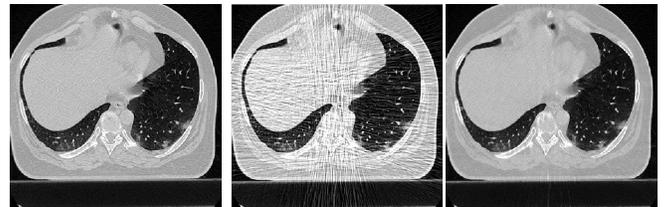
Representative transverse views of the full-dose, low-dose and predicted full-dose CT images from left to right, respectively.
